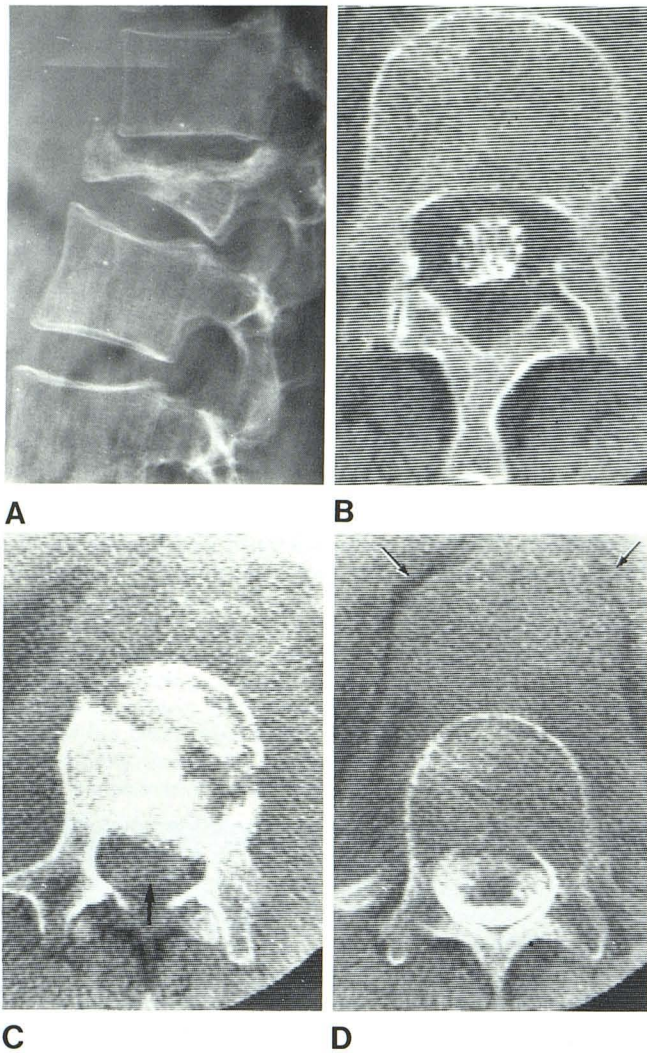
Extradural thoracolumbar lymphoma in 60-year-old man. A, Lateral radiograph showing severe compression and destruction of body of L1. B, CT myelography at L2. Opacified thecal sac is concentrically compressed by thickening of extradural soft tissues. C, At L1. Destruction with pathological fracture involving body of L1. Displaced posterior portion of vertebral body encroaches upon spinal canal. Thecal sac is severely compressed and barely recognizable (arrow). Conventional myelographic images demonstrated extradural block at this level. D, At T12. Extradural soft-tissue mass impinges upon anterior aspect of thecal sac which is opacified above level of apparent block. Also extensive soft-tissue mass surrounds external margins of vertebral body, bulges diaphragmatic crura (arrows), and obscures margins of aorta.
